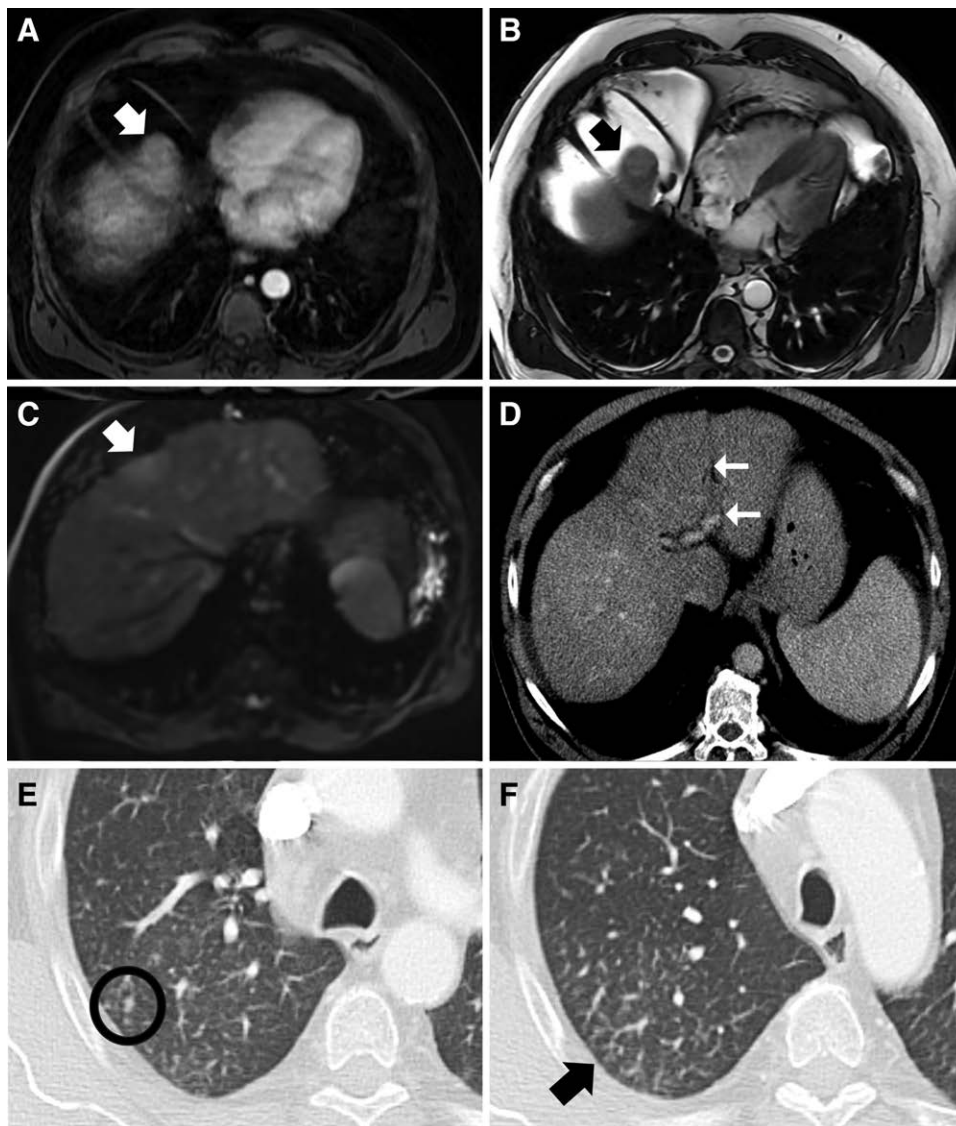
Preoperative magnetic resonance imaging and computed tomography studies. A and B, 3.4×3.0 cm arterially enhanced segment 8 lesion demonstrates washout and pseudocapsule. It is categorized as an liver imaging reporting and data system-5 and organ procurement and transplantation network (OPTN)-5B lesion in arterial phase and T2-weighted imaging, respectively (arrows). C, A white arrow indicates that it is adjacent to a lesion of capsular retraction in segment 8, which is categorized as an LR-3 and OPTN-3 lesion (diffusion-weighted imaging). D, There is a filling defect in the distal left portal vein (between arrows). E, An indeterminate nodule (encircled). F, Interlobular septal thickening in the right upper lobe.
